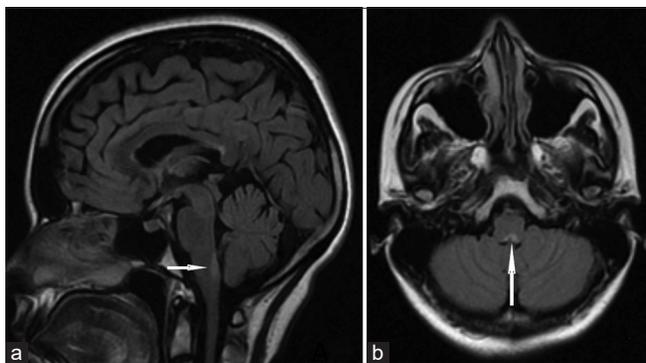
(a) Magnetic resonance imaging (MRI) brain T2 fluid-attenuated inversion recovery (FLAIR) sequence, sagittal view showing (arrow) hyperintensity at area postrema (dorsal medulla) and (b) MRI BRAINT2 FLAIR sequence, axial view showing (arrow) hyperintensity at area postrema (dorsal medulla).
